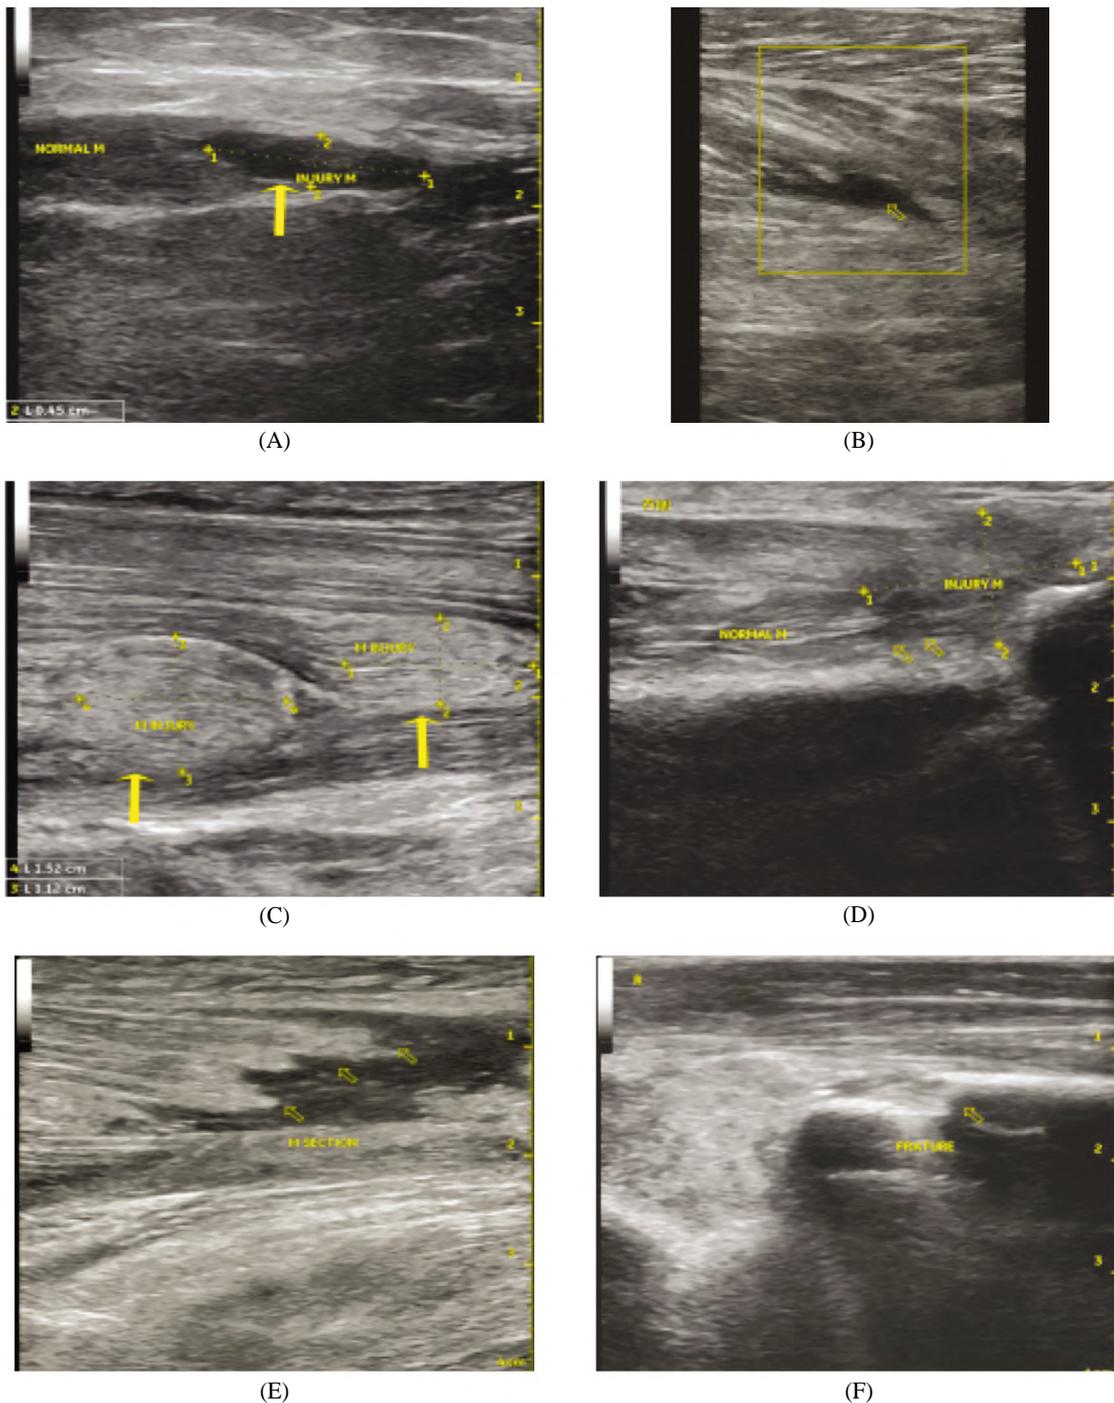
30 years old male patient came after road traffic accident, ultrasound image shows Grade I muscle rupture, but focal fibre rupture with less than 5% of the muscle involved; ultrasonography shows a hypoechoic mass within the muscle fibres (yellow arrow) (A, B). Grade II partial muscle rupture; the muscle belly forms a real mass, with focal fibre rupture with more than 5% but less than 30% of the muscles involved. Ultrasonography shows a hypoechoic mass within the muscle fibres (yellow arrow) (C, D). Grade III lesion represents focal fibre rupture with more than 30% of muscle rupture with retraction, and it also shows the bell-clapper sign, with torn muscle fragments floating in the serohematic fluid (yellow arrow) (E). Ultrasonography shows a limb fracture, fracture of the radius (yellow arrow point) (F).
